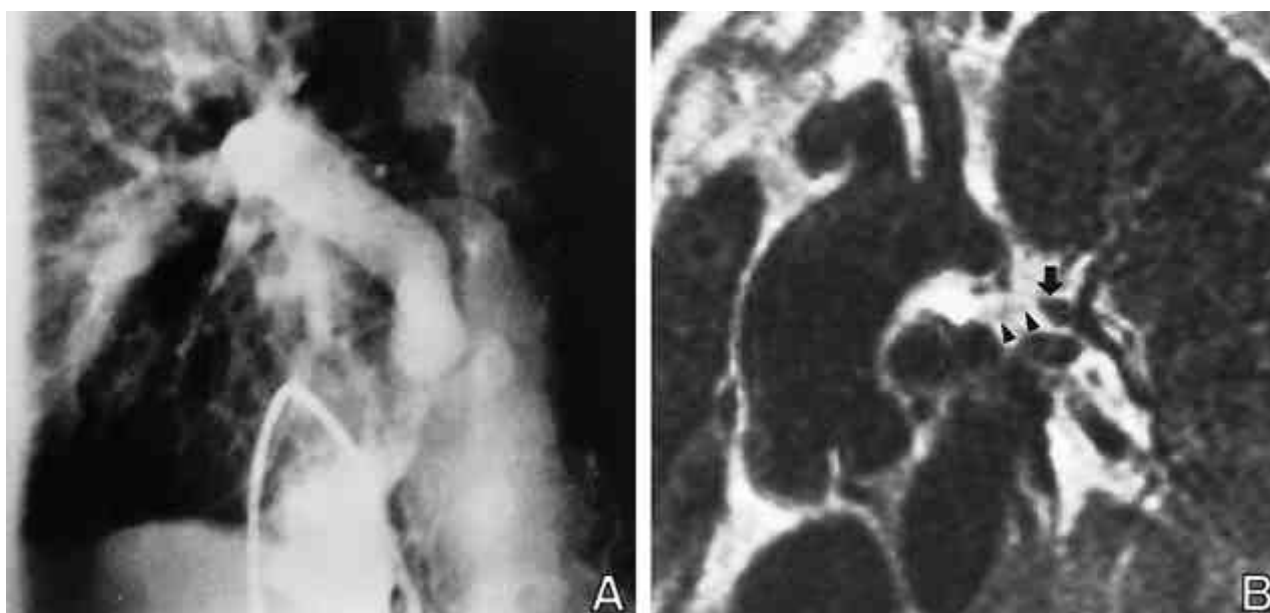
Proximal interruption of the left pulmonary artery in a patient with tetralogy of Fallot. A: Right ventriculogram shows absent left pulmonary artery. B: T1-weighted MR image in an oblique coronal plane shows the atretic segment (arrowheads) and patent distal lumen (arrow) measuring 5 mm.
